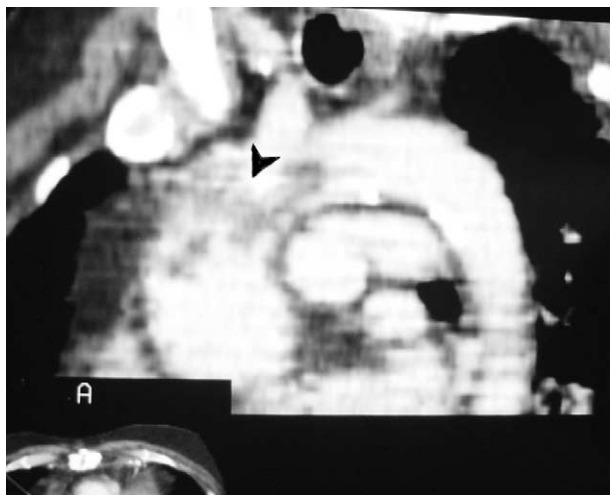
CT scan of thorax showing near total occlusion of the ascending aorta with vegetations (arrow).
